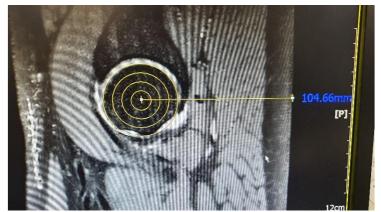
Measurement of hip joint height in HIP 3D Sagittal images of MRI
